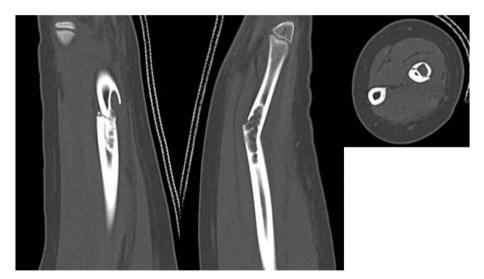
Computed tomography of the right forearm shows polycystic translucent lesions with thinning of the cortex and a pathological fracture through the middle of the tumor lesion.
